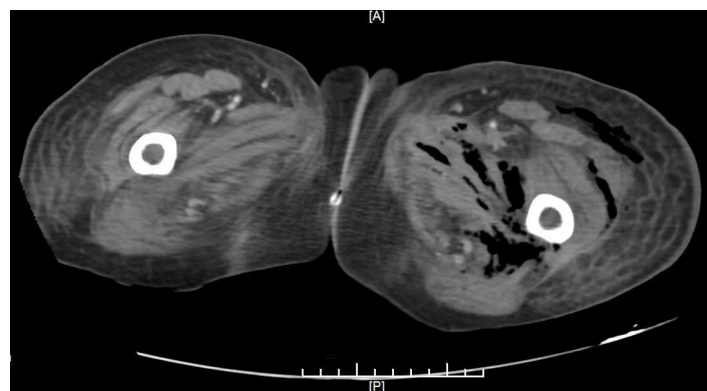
February 17 CT: left common iliac artery aneurysm thrombosis, significant edema, and pneumatization of soft tissues around the left hip, buttock and thigh.
